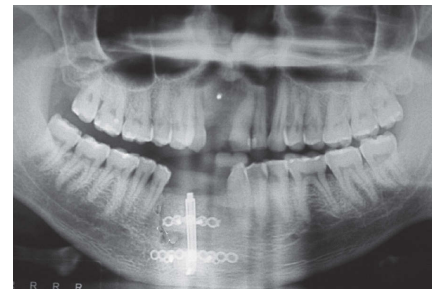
Radiograph after latency period showing growth achieved with the technique.
